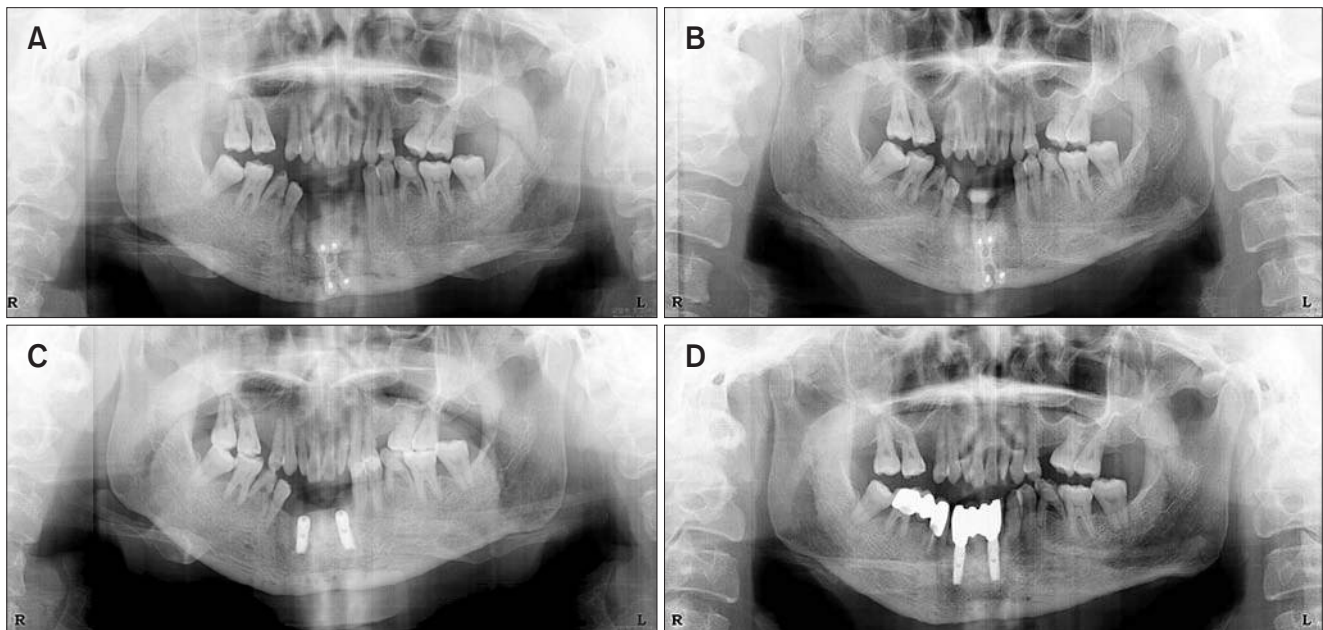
Panoramic radiographs from interpositional bone graft to final implant supported restoration. (A) Panoramic view after the interpositional bone graft. (B) Five months after vertical augmentation. (C) Implants were placed after about one year. (D) Two years after the final implant supported restoration.
